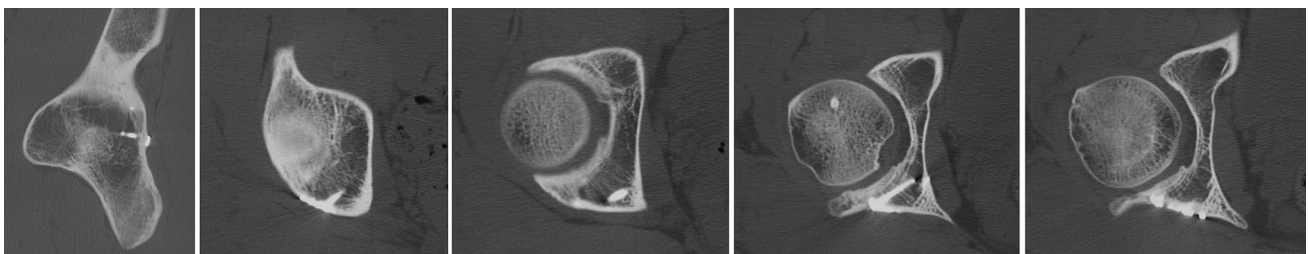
5-year follow-up CT-scan showing appropriate joint congruence. No signs of femoral head necrosis. Implants are intact and remain extra-articular
